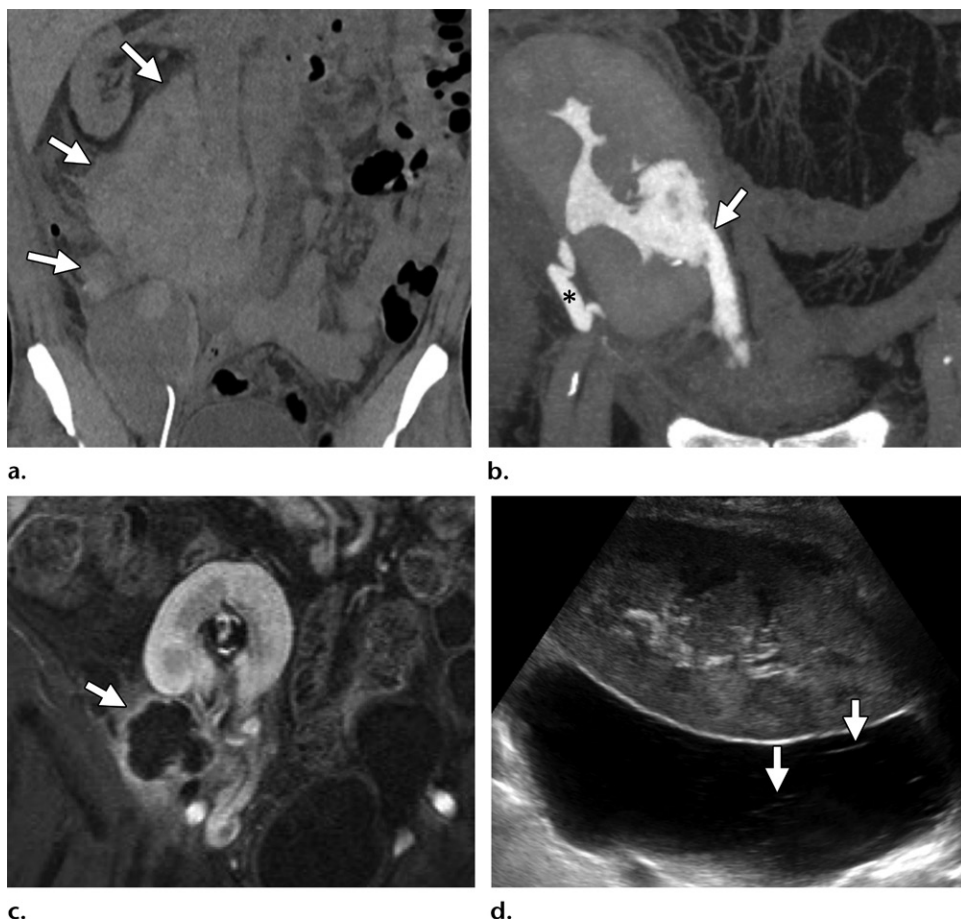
Four types of perinephric fluid collections. (a) Coronal nonenhanced CT image shows a hyperattenuating perinephric hematoma (arrows). (b) Coronal contrast-enhanced delayed phase MIP CT image shows focal urinary contrast material leak from the collecting system (arrow), which resulted in a dependent perinephric urinoma (not shown). Note the contrast material-filled transplant ureter (*). (c) Coronal gadolinium-enhanced T1-weighted MR image shows a peripherally enhancing thick-walled abscess (arrow). (d) Gray-scale US image shows a hypoechoic collection with thin echogenic septa (arrows), in this case without mass effect. Aspiration of the collection showed a creatinine concentration similar to that of serum levels, consistent with lymphocele.
